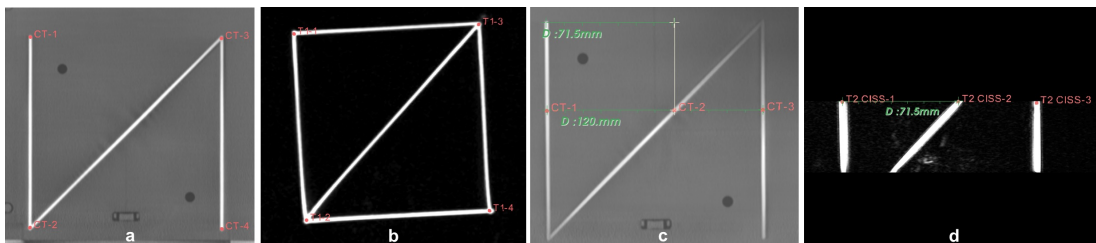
The chosen landmarks for the frame-based registration shown on the right side of the fiducials. The selected points for the landmark registration between CT and T1w are presented in (a) and (b), and in (c) and (d) those for the CT-T2 CISS matching along with the measurements done for this purpose.
